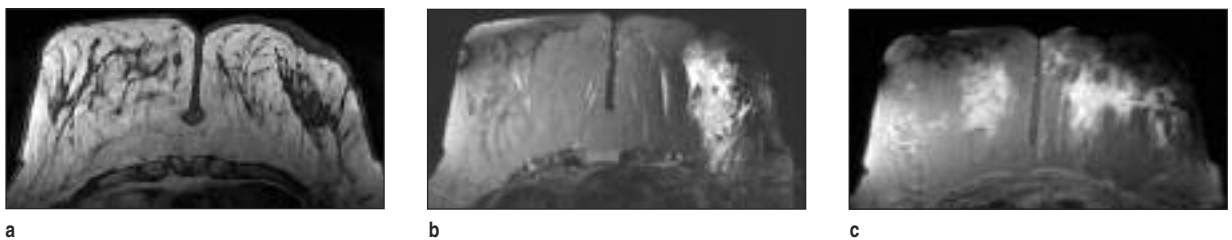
MRI images of the patient with IGM of the left breast a. Asymmetrical tissue of low signal intensity on the lateral aspect of the left breast is seen on axial T1 weighted image b. On axial T2 weighted fat suppressed images the lesion is seen as heterogeneously hyperintense. c. Axial fat suppressed T2 weighted image of a different patient demonstrates increased segmental heterogeneity of both breasts.
